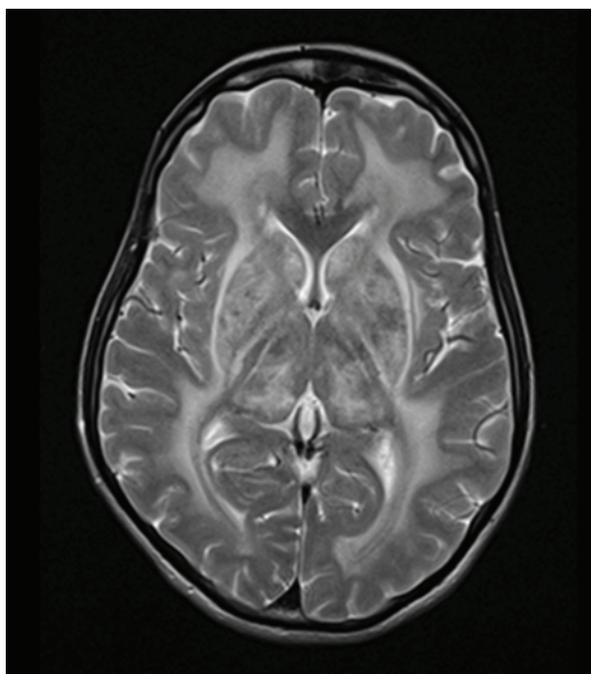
T2-weighted MRI brain showing bilateral leukodystrophy of the proband
